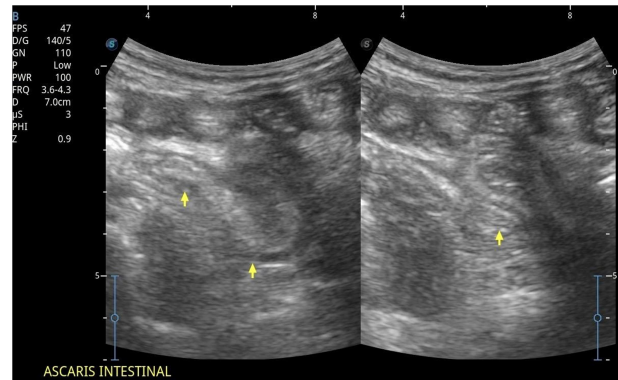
Abdominal ultrasound showing a tubular, hyperechoic, mobile structure consistent with *Ascaris lumbricoides* located within the intestinal lumen.
